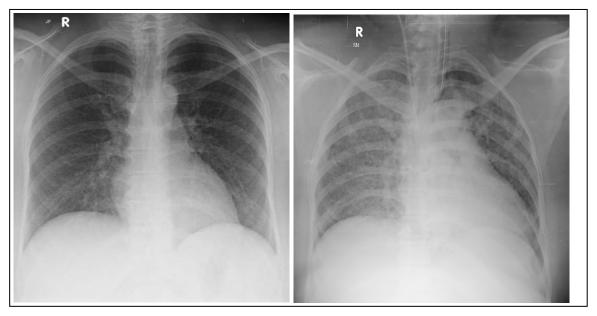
Left. Normal Chest X-ray at the time of admission to our hospital and Right. Image shows Chest X-ray with miliary mottling taken post operatively
